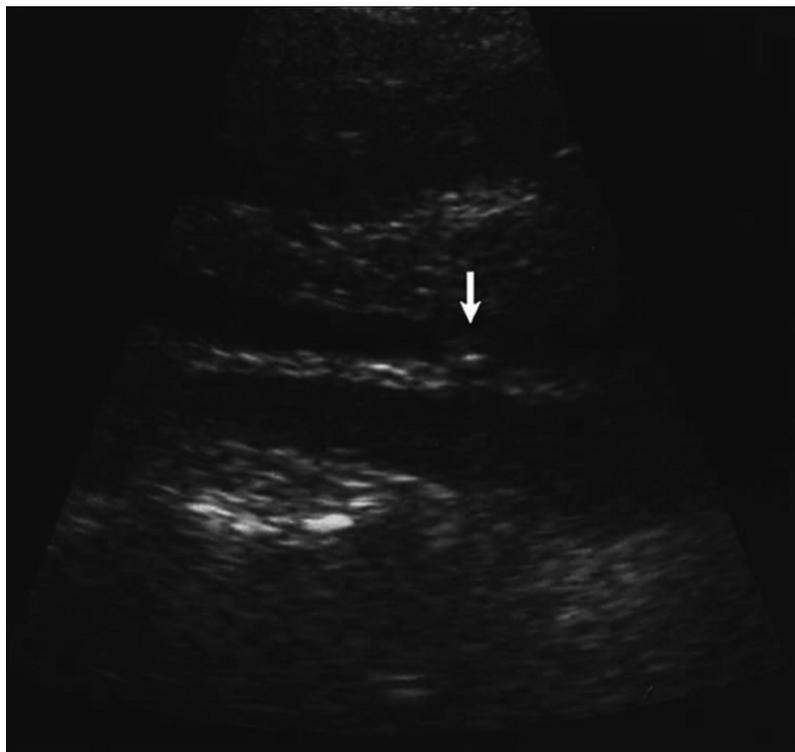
Transabdominal ultrasound demonstrating gallstone (arrow) in the CBD.
